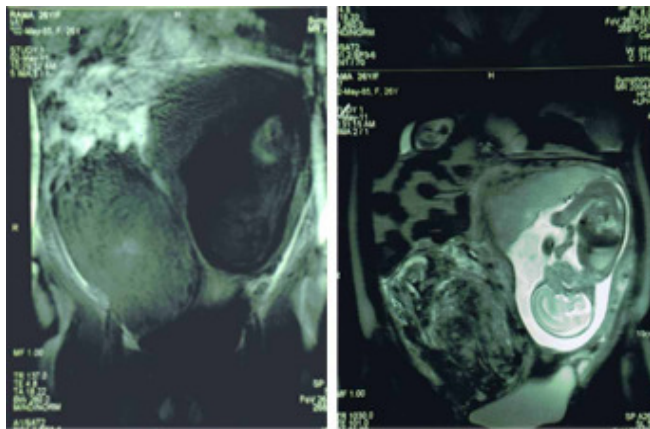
A & B . MRI revealed intra placental mass isointense on T1W Image and heterogenous signal intensity mass on T2W Image
